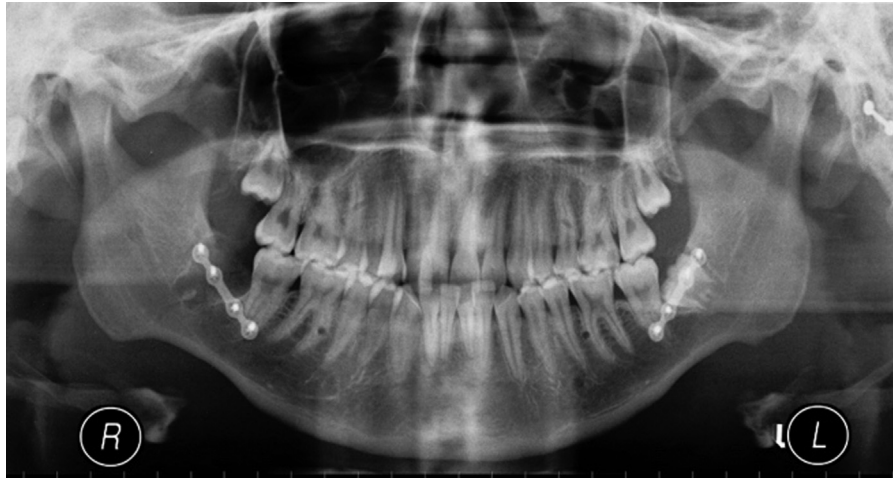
Panoramic radiograph depicts root dentine involvement of the LR6, LL6, UL5 and UR5.
